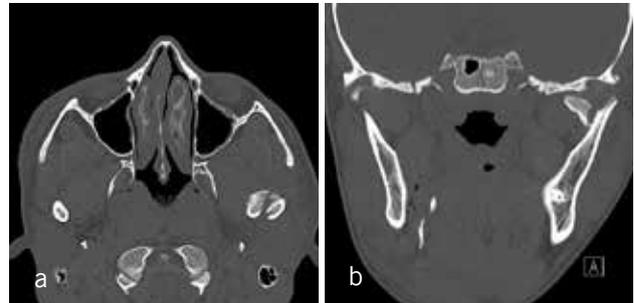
Case series of figure 6 continued: preoperative situation left condylar head fracture type p with displacement and vertical loss, a) CT axial view; b) CT coronal view.
